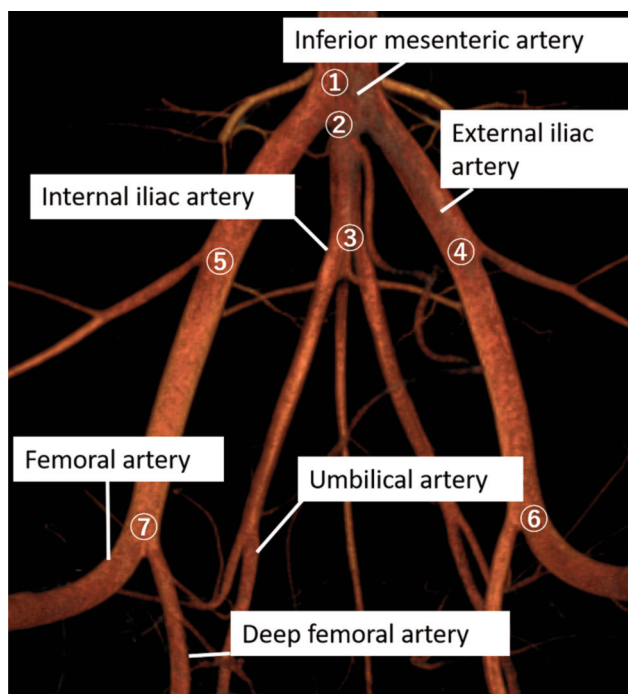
A three-dimensional blood vessel image that identifies the seven arterial bifurcations in the pelvic arteries (inferior mesenteric, external and internal iliac arteries) is edited using a computed tomography workstation (Ziostation, Ziosoft Inc., Tokyo, Japan).
